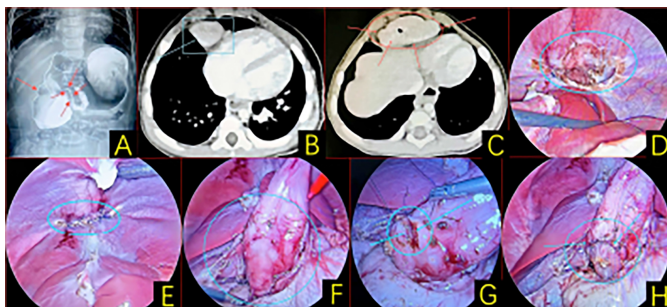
(A) Abdominal x-ray and contrast: Abdominal 'double bubble' sign, dilatation of duodenum bulb, narrowing of duodenum descending section, and low passage of contrast. (B, C) Abdominal CT: Liver and part of adipose tissue embedded in the thoracic cavity. (D) Morgagni's foramen defect was detected, and the left hepatic lobe and adipose tissue were herniated out. (E) The hernia contents were repositioned into the abdominal cavity, and the defect was closed using interrupted sutures. (F) Blunt separation of the descending and horizontal segments of the duodenum and a stenotic segment were found. (G, H) Resection of the stenotic segment and continuous suturing of the duodenal wall.
